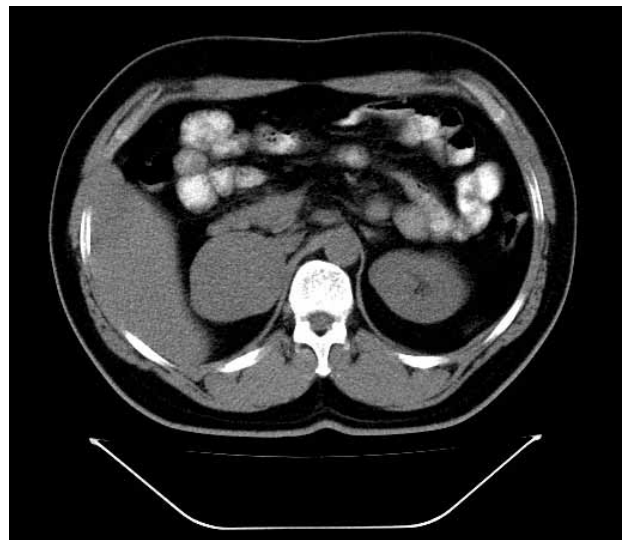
Abdominal CT showing tumour in the right adrenal gland area
